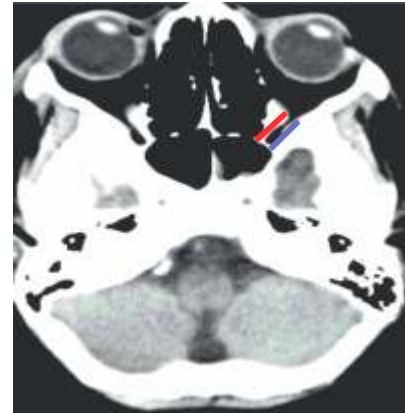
Axial CT slice showing the measurement of the length of the medial wall (red), length of the lateral wall (blue)
